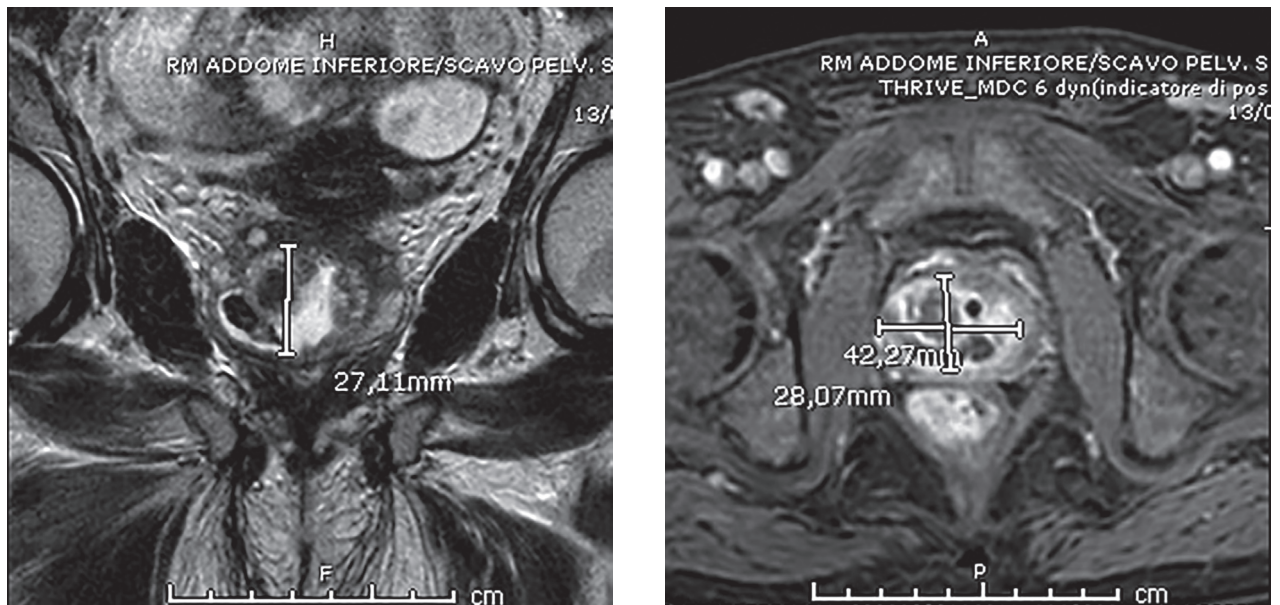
MRI of inferior abdomen and pelvic cavity: nodulation to the middle prostatic lobe, with heterogeneous signal intensity characterized by colligate areas and areas with haemorrhagic content, having transverse diameters of about 4.2 x 2.8 cm and longitudinal extension of about 2.7 cm. The nodulation appears capsulated, without significant restriction to the evaluation of diffusion but with fair contrast enhancement predominantly peripheral and paramedian left. The peripheral glandular part appears poorly represented from the right side, that is compressed by the described nodulation. The left peripheral glandular part is more represented, with low-intensity focal length in T2 sequences weighed about 3 mm showing restriction of signals to the evaluation of diffusion and discrete contrast enhancement (PIRADS=4).
